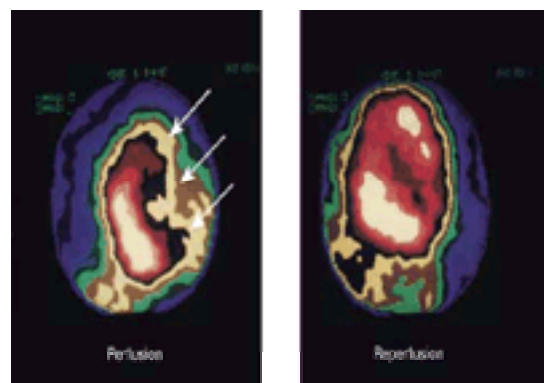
Thallium perfusion scintigraphy on exercise (left; perfusion) and recovery (right; reperfusion) showing reversible myocardial ischaemia. A large area of low isotope uptake on exercise (arrowed) fills in on recovery showing ischaemia of the anterior left-ventricular wall. Right oblique projection.
